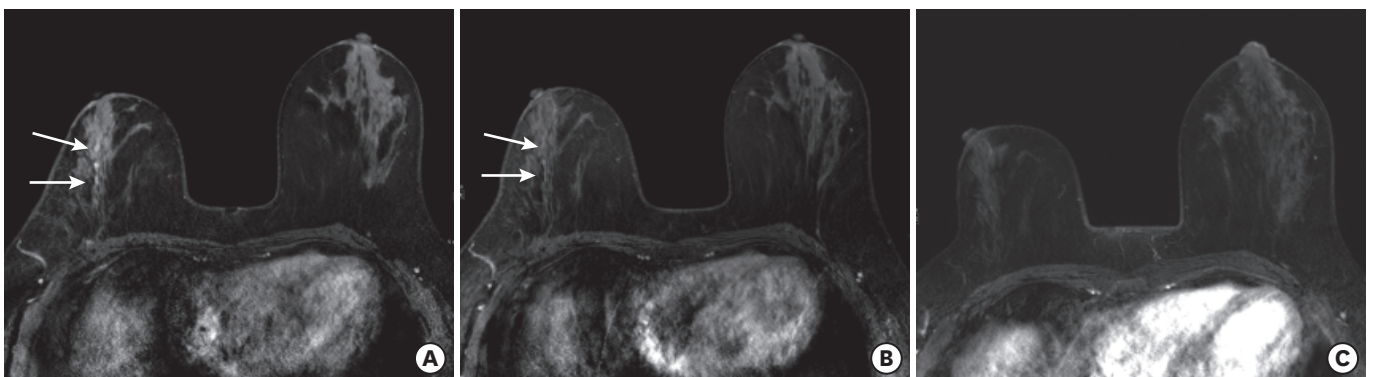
A 30-year-old premenopausal woman whose biopsy was canceled. (A) Axial T1-weighted fat-suppressed contrast-enhanced screening MR images after right breast-conserving surgery showed linear non-mass enhancement in the right mid outer breast on the delayed phase image (arrows). The lesion is categorized under BI-RADS 4A. (B) On the day of the scheduled biopsy (1.5 month after the previous MRI), the degree of enhancement of the lesion decreased, and the lesion became less prominent (arrows). Benign reactive enhancement along the duct as a post-operative change was considered, and the biopsy was then canceled. (C) On the follow-up MRI within 5 years, the lesion disappeared. MR = magnetic resonance; BI-RADS = Breast Imaging Reporting and Data System; MRI = magnetic resonance imaging.
